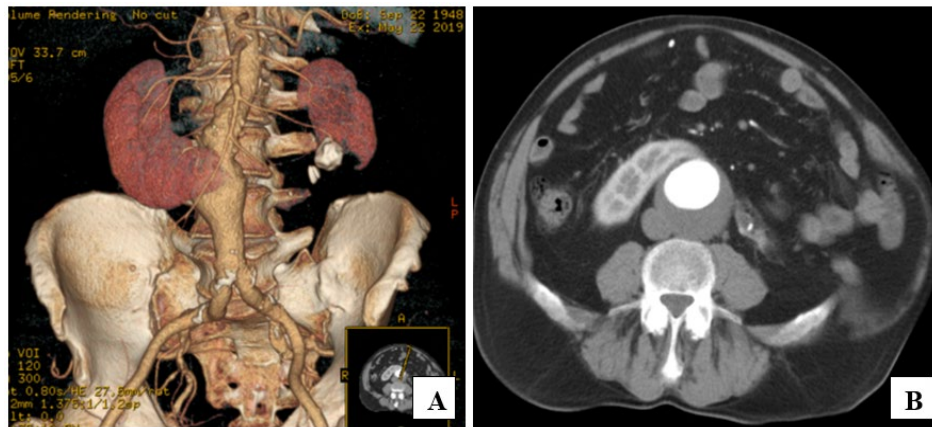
Abdominal CTA: A, B – AAA with concomitant HSK
